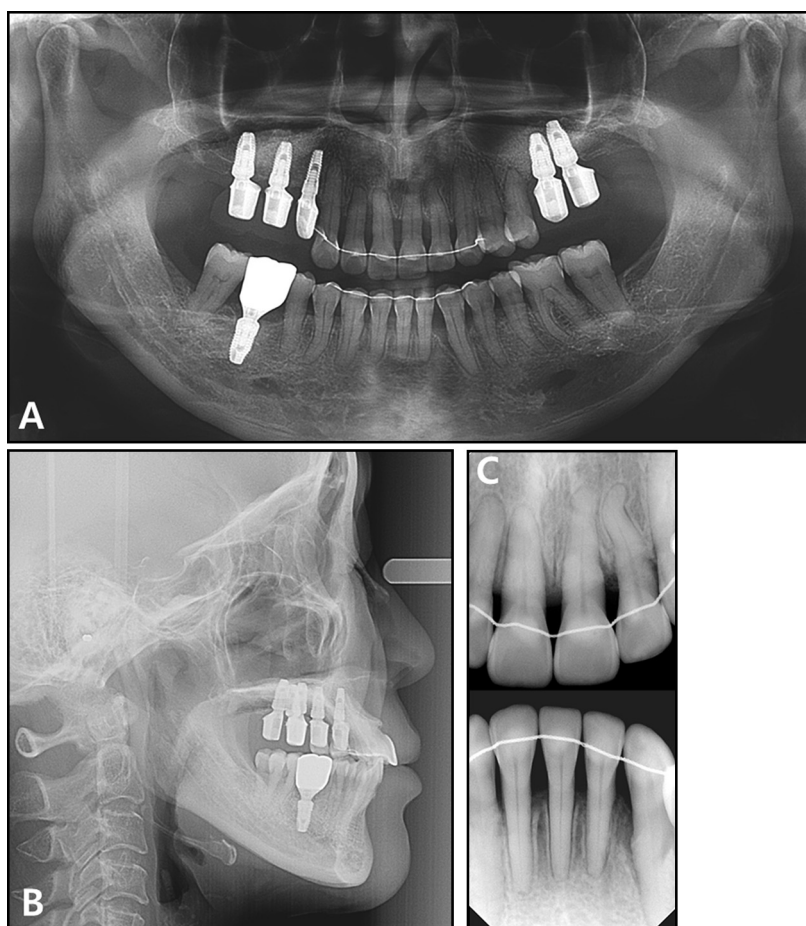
Posttreatment radiographs: A, panoramic radiograph; B, lateral cephalogram; C, periapical radiographs.
